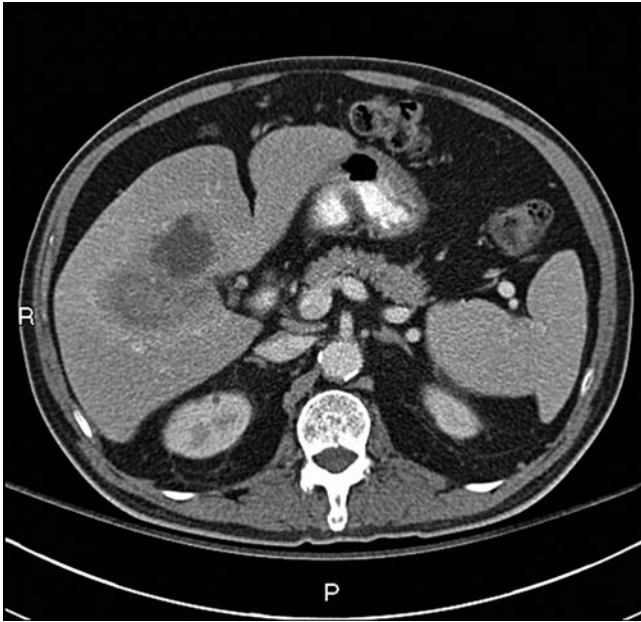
A 73-year-old man with fever. Axial computed tomography (CT) image with contrast administered orally and intravenous (IV) demonstrates an abscess in the central liver. The posterior component is less liquified centrally than the anterior component and is associated with thrombosis of a portion of the right portal venous system
